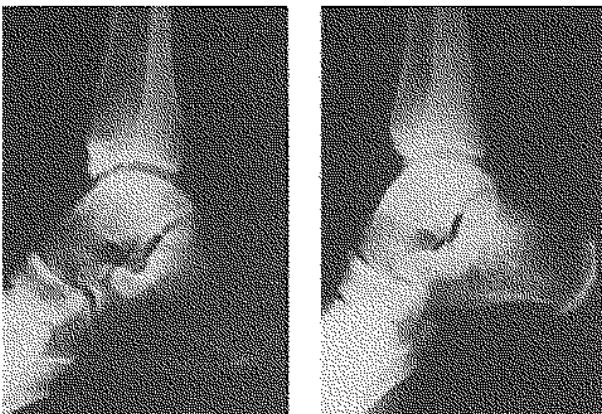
Lateral radiograph of ankle showing large anterior tibial exostosis.
